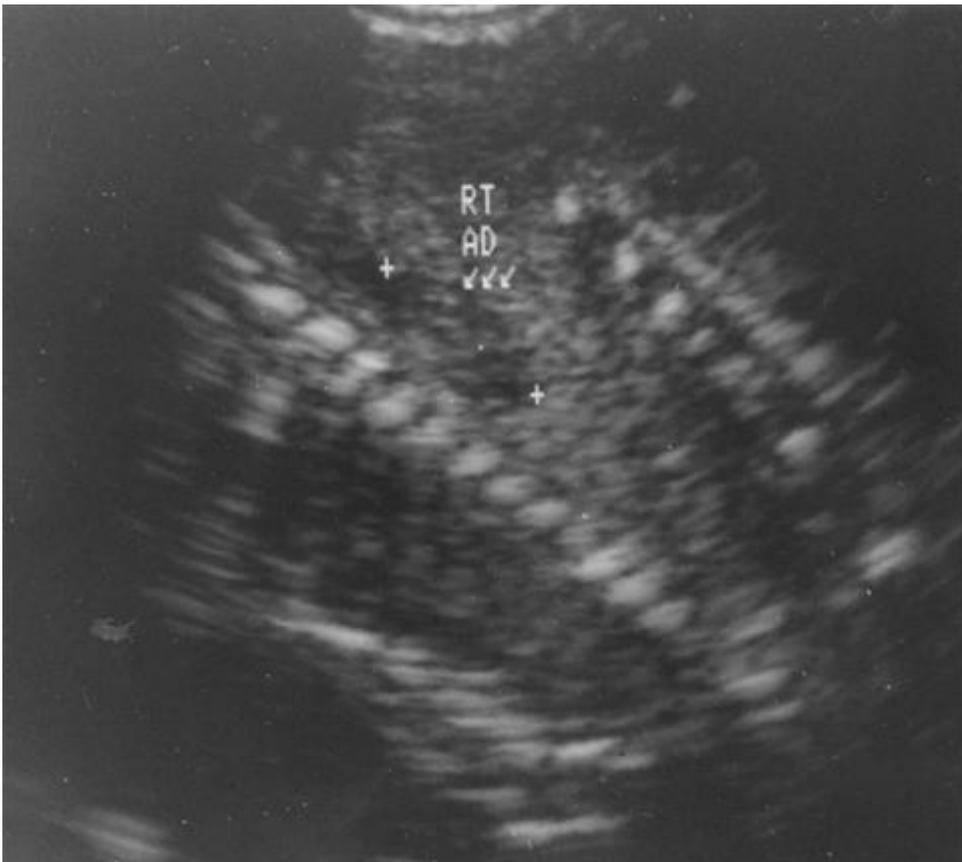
Transvaginal ultrasound of the right adrenal (RT AD). The right kidney is not present within the renal fossa. Click for larger image.
